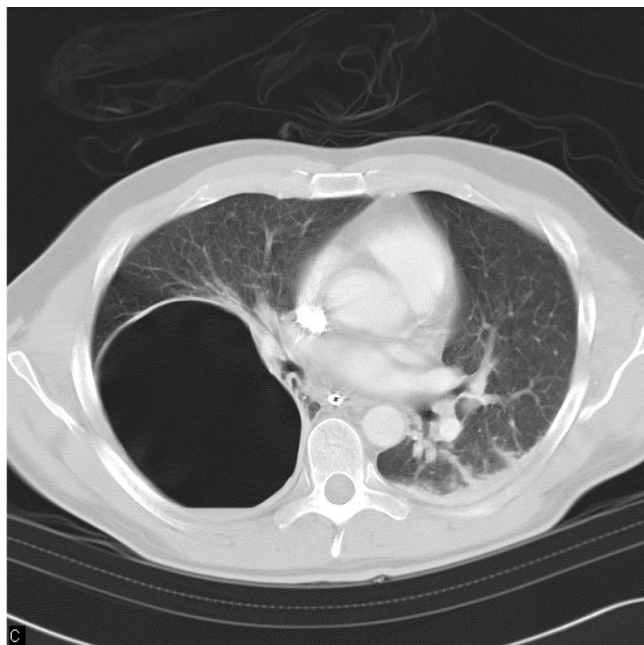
Computed tomography scan of the chest with a cystic intrapulmonary bulla of the lower inferior right lobe.
